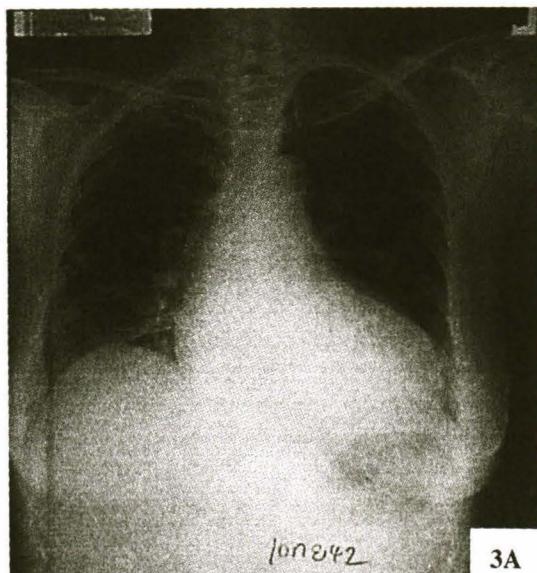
Chest X-ray 30 months before biventricular pacemaker.
